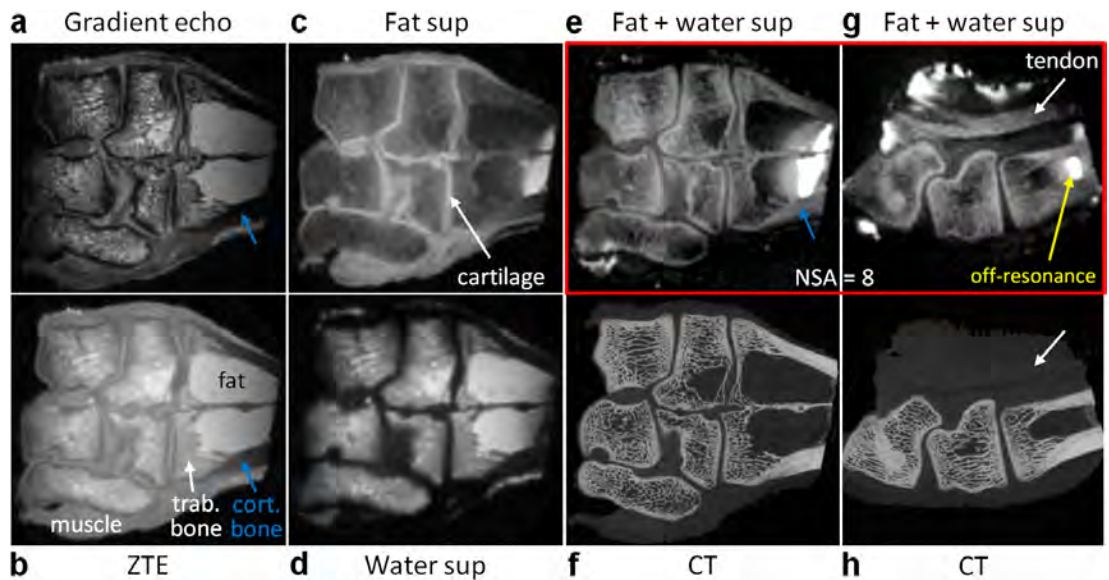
(a) Gradient echo and (b)-(e)+(g) ZTE imaging of a lamb joint with different suppression options; (f)+(h) μ CT data.
